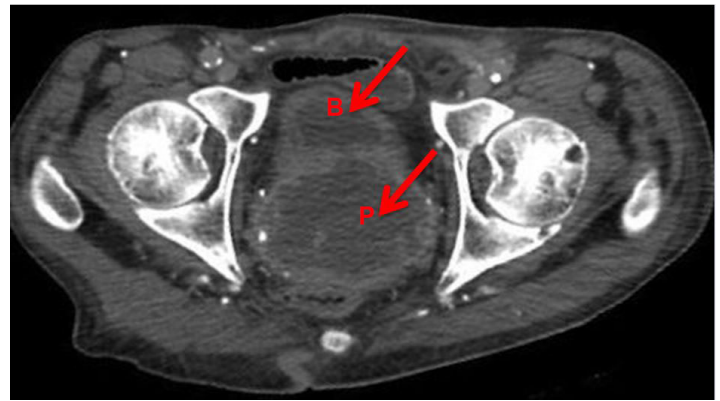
Axial computed tomography demonstrates persistent abscess within the bladder and prostate after spontaneous urethral drainage, with communication between the bladder (B) and prostate (P) abscesses.
